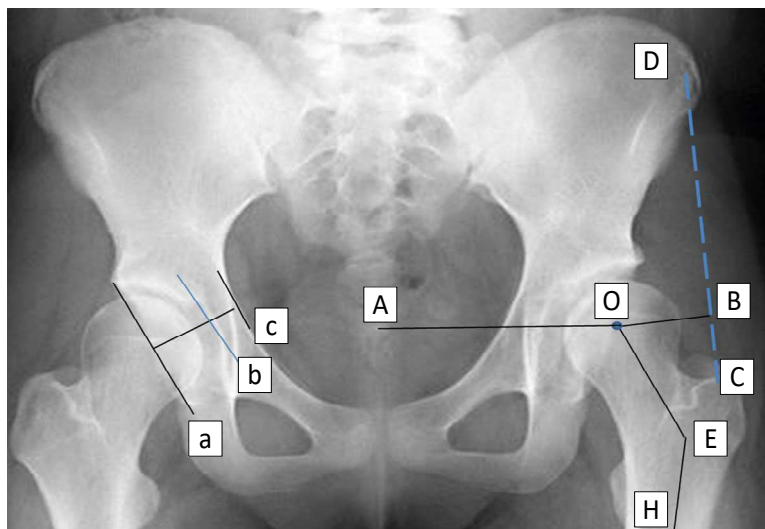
Scheme of X-ray measurements.
